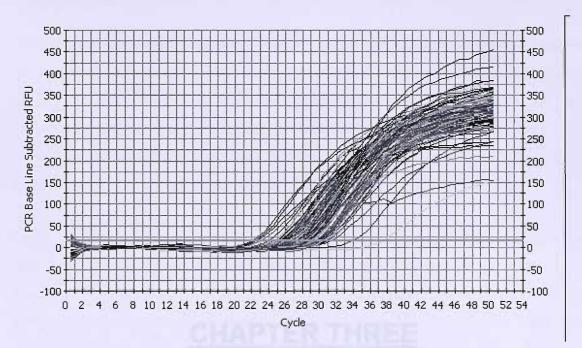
shows a typical Taqman PCR trace. The CT value is determined from the point at which the curve rises above baseline. This is then used to calculate gene expression.
